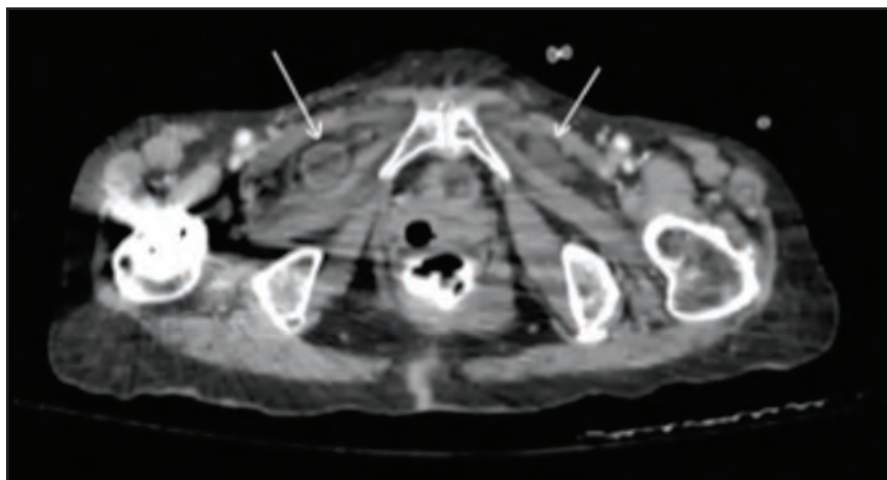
CT abdomen axial view shows right and left fluid-filled loop seen between right and left pectineus and obturator muscles respectively, representing bilateral obturator hernia (white arrows).
